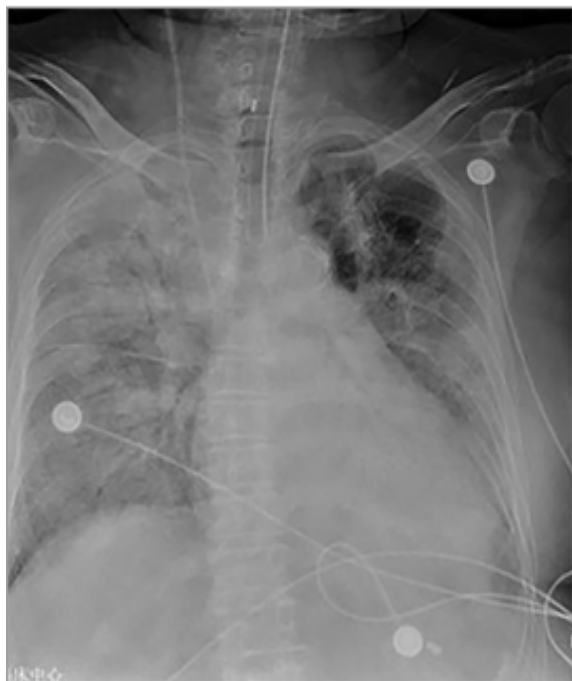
79-year-old woman who presented with chest pain, cough, and fever for 3 days. Coronavirus disease (COVID-19) had recently been diagnosed in two of her household members. Patient developed acute respiratory distress syndrome within subsequent few days and died 11 days after admission. (Courtesy of Song F, Shanghai Public Health Clinical Center, Shanghai, China) CT image
